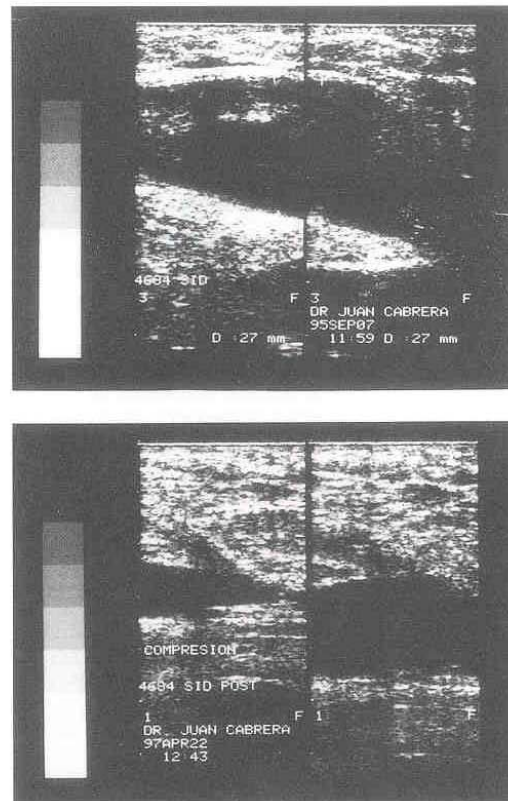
Ultrasonographic images showing the evolution to fibrosis (from top to bottom).
